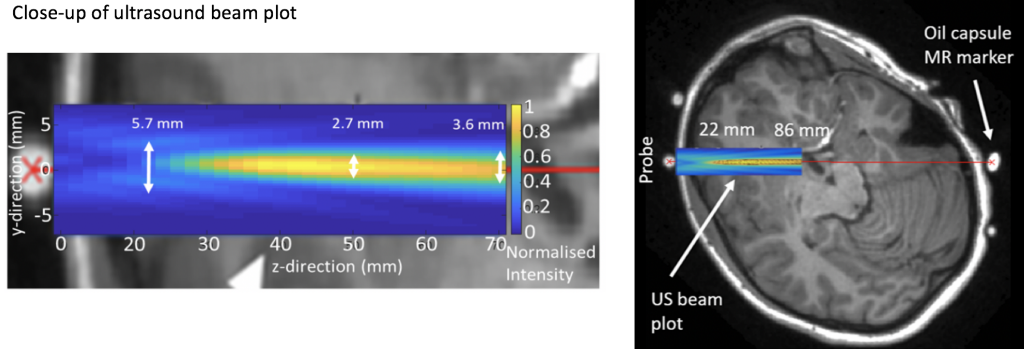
Close-up of a free-field beam plot displaying normalised intensity along the direction of the beam. The Full Width Half Maximum (FWHM) is provided for 3 depths, showing how beam width varies along the ultrasound beam path. The path of the free-field ultrasound beam has been superimposed on a resampled MR image showing brain anatomy on the right. N.B. It should be noticed that in reality the beam will be distorted somewhat by the skull.
